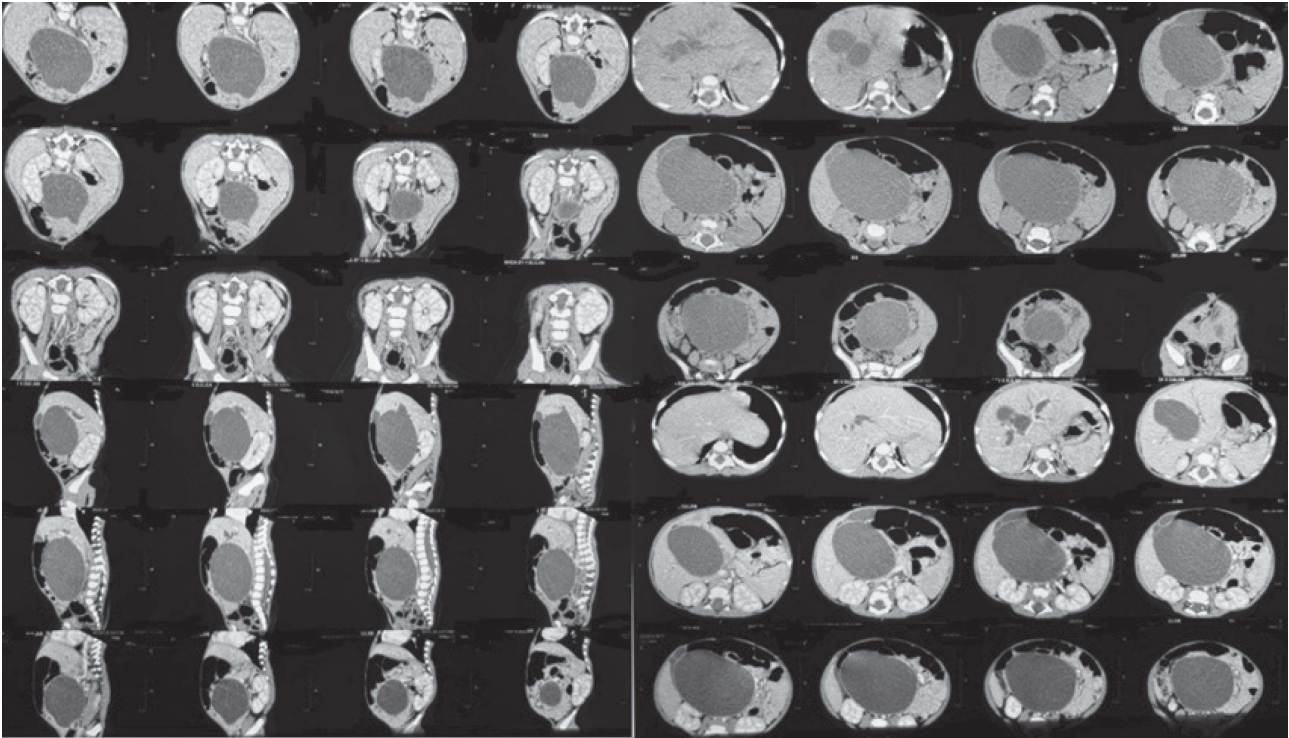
Abdominal computed tomography (CT) scan showed a choledochal cyst.
